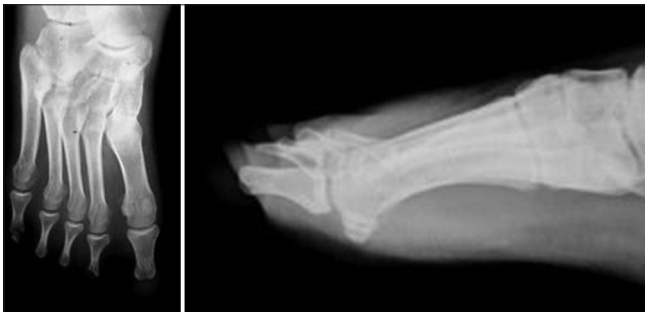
Radiograph anteroposterior and lateral views of left feet showing absence of distal phalanx of all the toes with absence of middle phalanx of toes 1-4, hypoplasia of the middle phalanx of 5th toe and normal metatarsals
